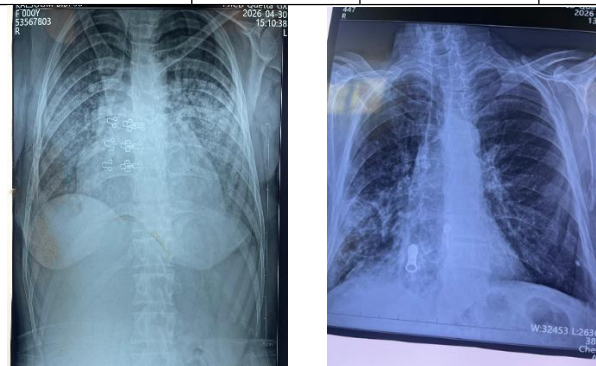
Chest X-ray showing multilobar infiltrates among a patient with community-acquired pneumonia.
